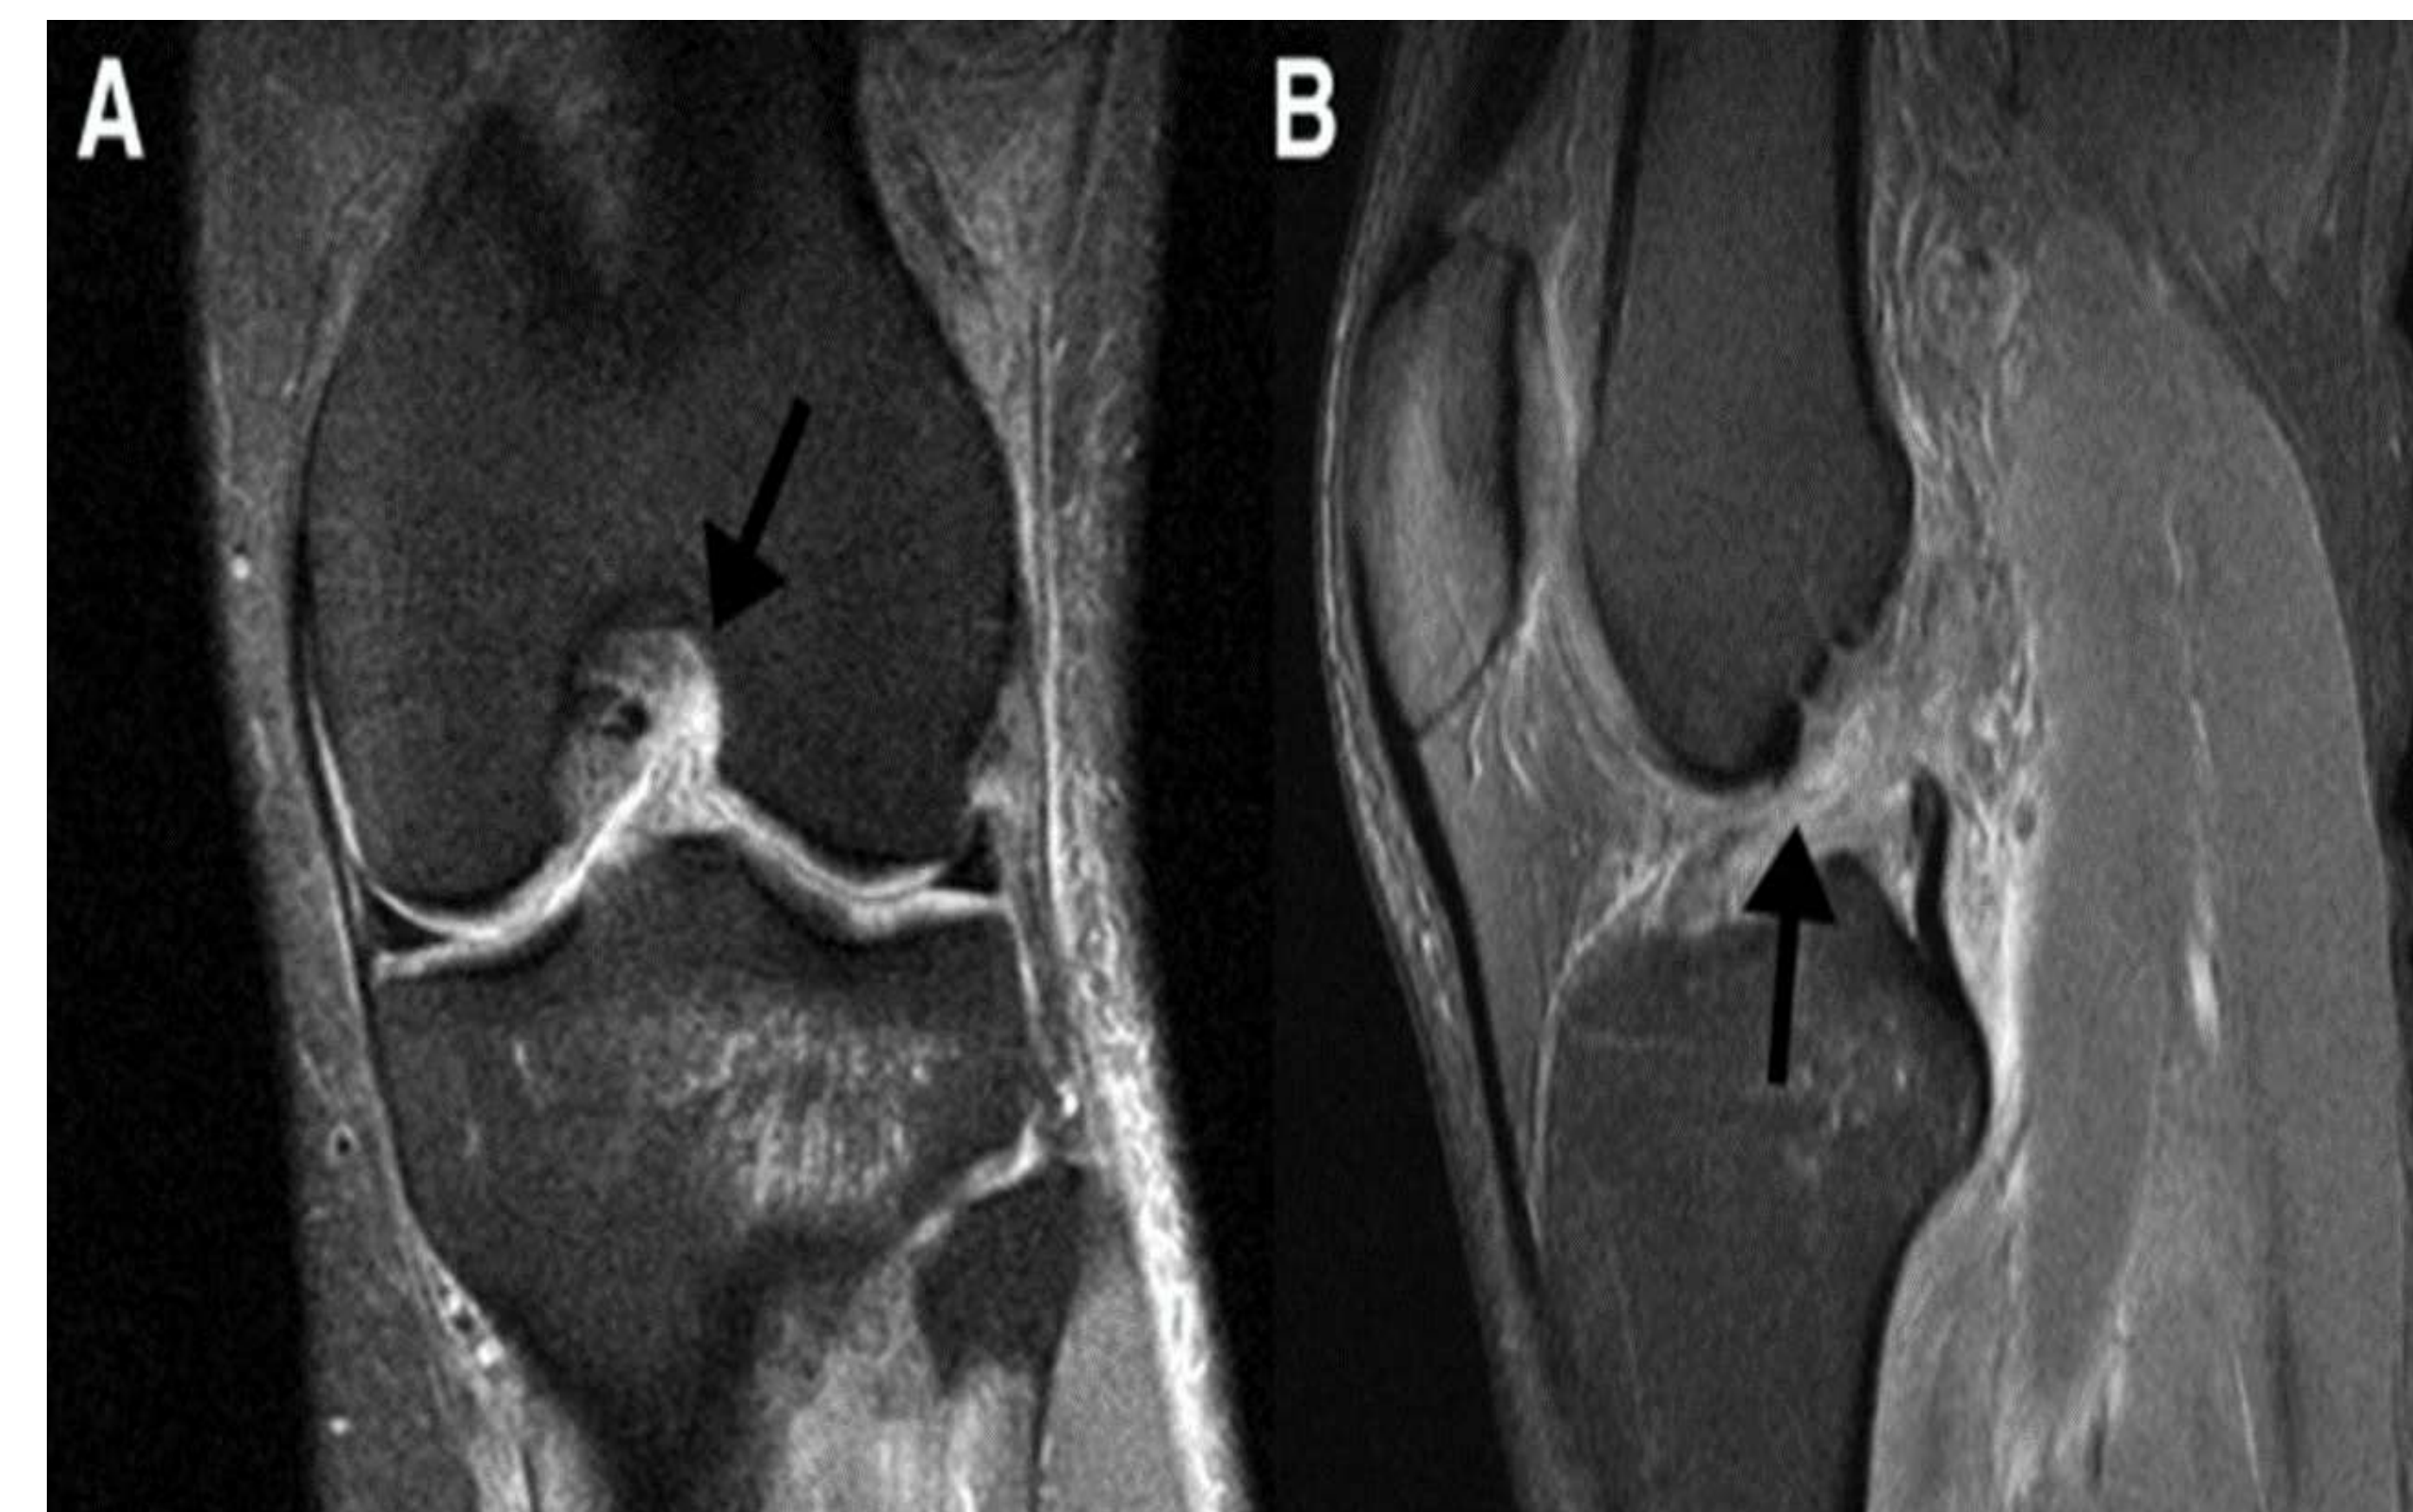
shows Preoperative (A) coronal and (B) sagittal magnetic resonance imaging slices of the left knee showing a torn anterior cruciate ligament (black arrows) with fiber discontinuity.²
